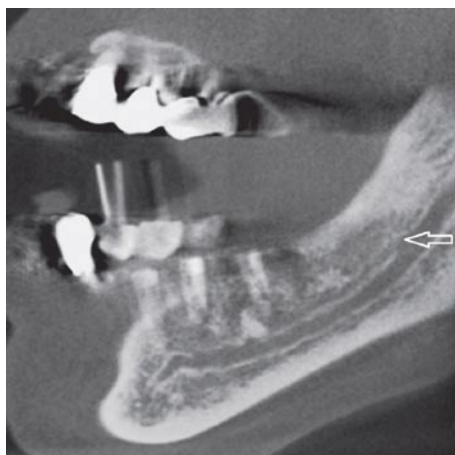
Cone beam computed tomography exam with a white arrow pointing the origin of a forward canal without confluence, bifurcated from the main mandibular canal in the ramus region, and classified as type 3 by Naitoh *et al*^[15] (2009).
